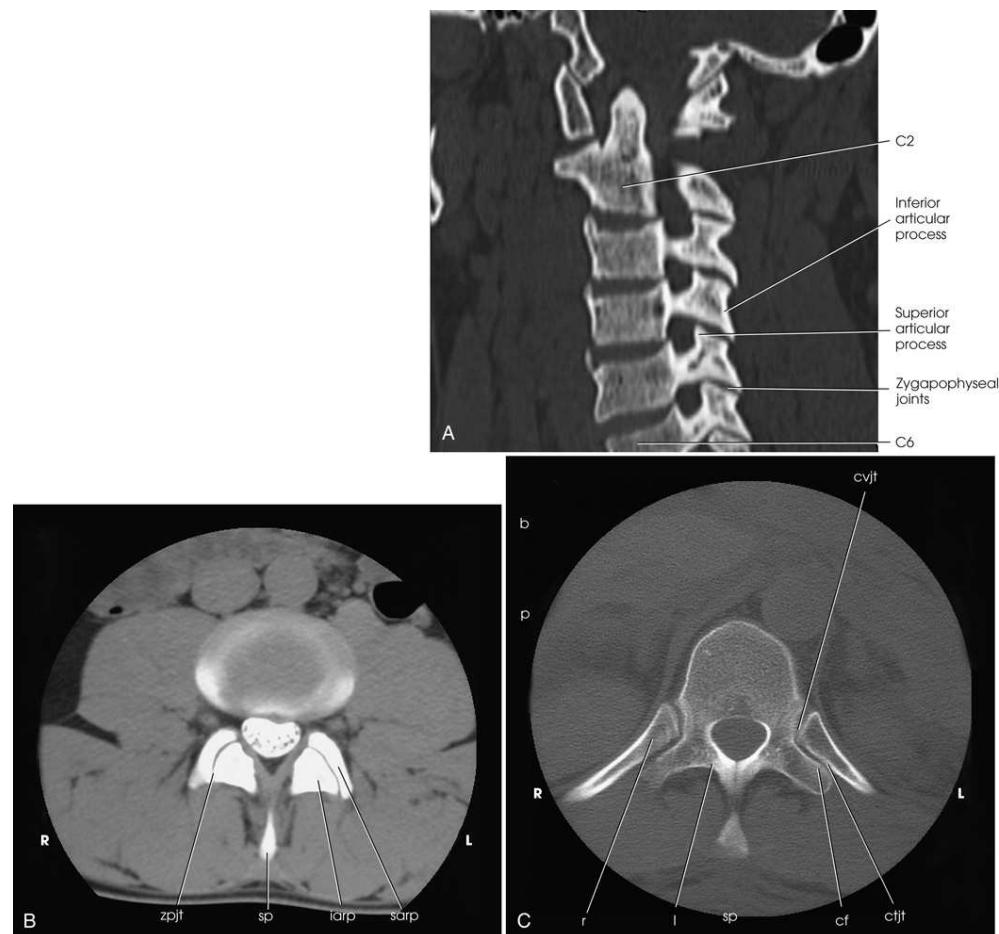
Vertebral articulations. (A) CT reformat of cervical spine showing zygapophysal joints. (B) CT scan of lumbar spine showing zygapophysal joints. *iar*p, Inferior articulating process; *sarp*, superior articulating process; *zpj*t, zygapophysal joint. (C) CT scan of thoracic vertebra. *cf*, Costal facet; *ctjt*, costotransverse joint; *cvjt*, costovertebral joint; *l*, lamina; *r*, rib.
